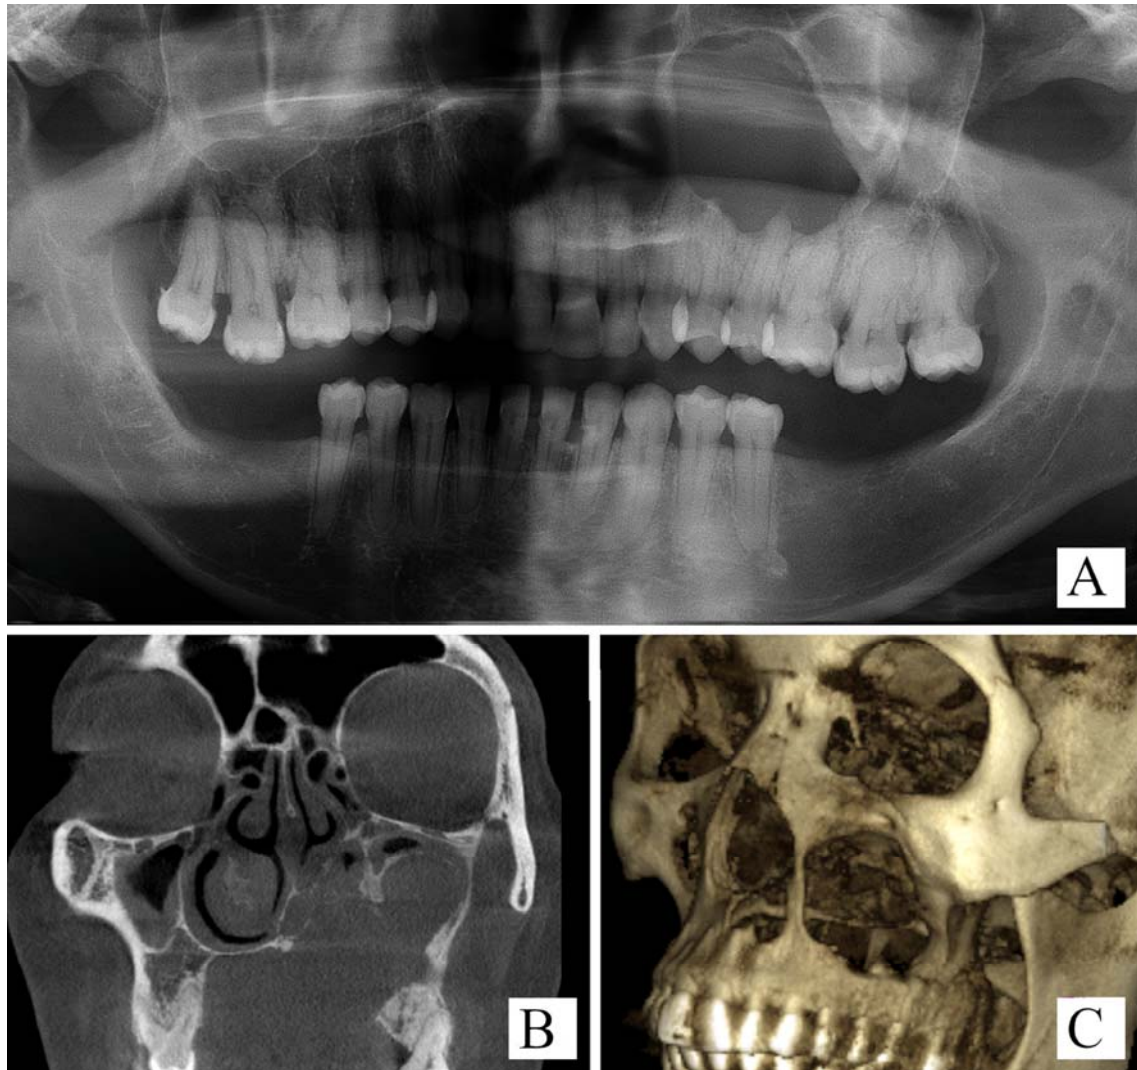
Maxillary GOC in a ‘globulomaxillary’ relationship. The panoramic radiograph (A) and the coronal (B) and 3-dimensional (C) reconstructed CBCT images reveal radiological signs of cortical destruction and encroachment into the nasal cavity and maxillary sinus.
